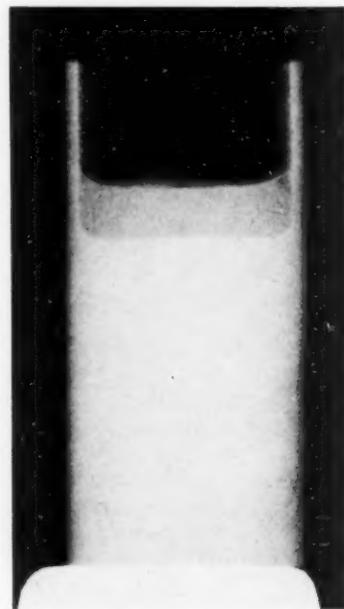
Roentgenogram showing aqueous fluid, fat and hair removed from cyst and incubated at 37.5°C . for twenty-four hours. Before the tumor was opened for inspection it had been chilled to below room temperature. Under these conditions no fluid fat was found but instead a viscous aqueous fluid in which were floating clumps of hair and yellowish fat resembling butter. Figure 4 demonstrates that at body temperature these lumps of solid fat become fluid and float on the aqueous portion as a cream.
